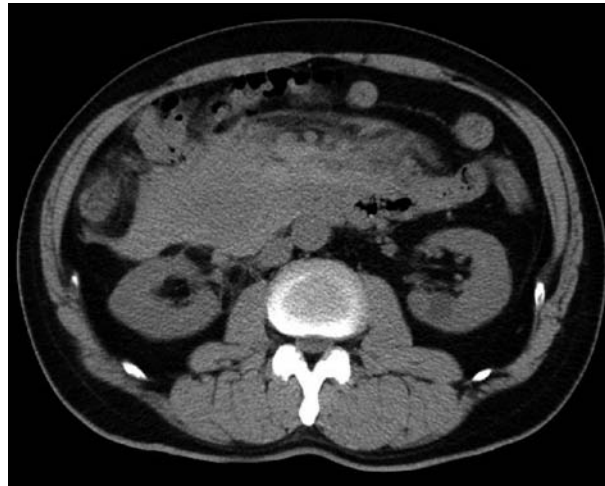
Plain CT showing fluid retention in the anterior pararenal extraperitoneal space and around the pancreas head.
